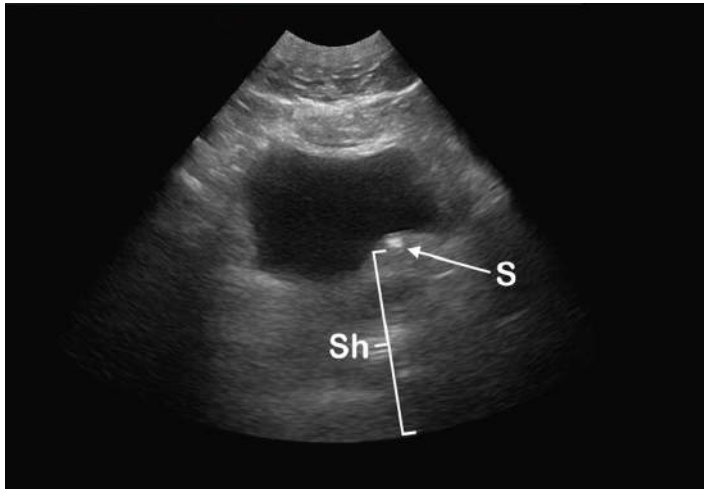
Emergency department ultrasound (EDUS). Direct stone visualization (S) with shadowing (Sh) and protrusion of the left posterior bladder wall.
